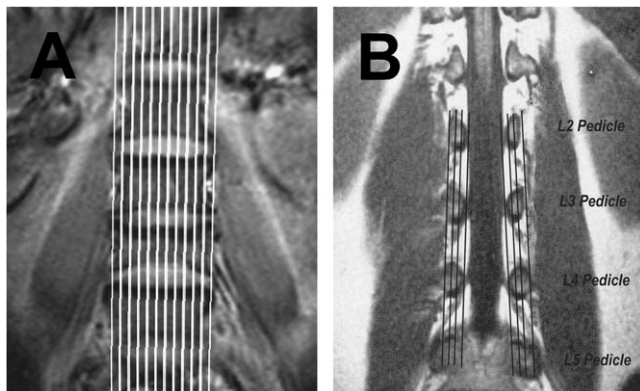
Coronal templates to prepare sagittal cuts in MRI. A, The usual way a technician will prepare sagittal cuts; B, the proposed way to prepare sagittal cuts.
